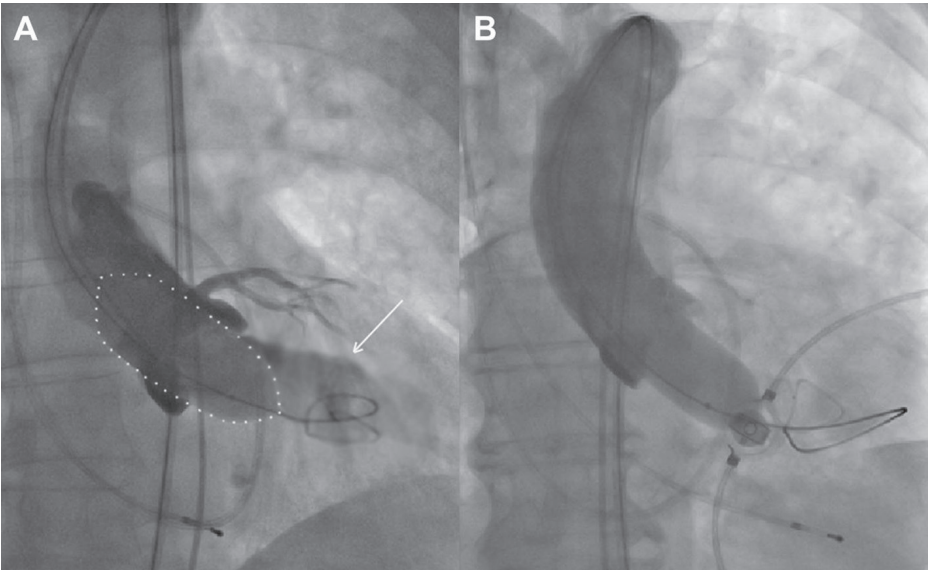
Supra-aortic angiography during balloon aortic valvuloplasty (BAV) for prosthesis size selection. (A) A 23-mm balloon (white dotted line) was chosen for a preparatory BAV according to the 2-dimensional transesophageal echocardiography (2D TEE) data on the aortic annulus size. Concurrent supra-aortic angiography, showing contrast regurgitation into the left ventricle (white arrow), indicated annulus size underestimation by 2D TEE and resulted in the selection of a bigger prosthesis. (B) Absence of contrast regurgitation into the left ventricle during BAV with a 23-mm balloon confirmed correct annular sizing based on pre-interventional 2D TEE. Reproduced with permission from Patsalis *et al.*³⁶
